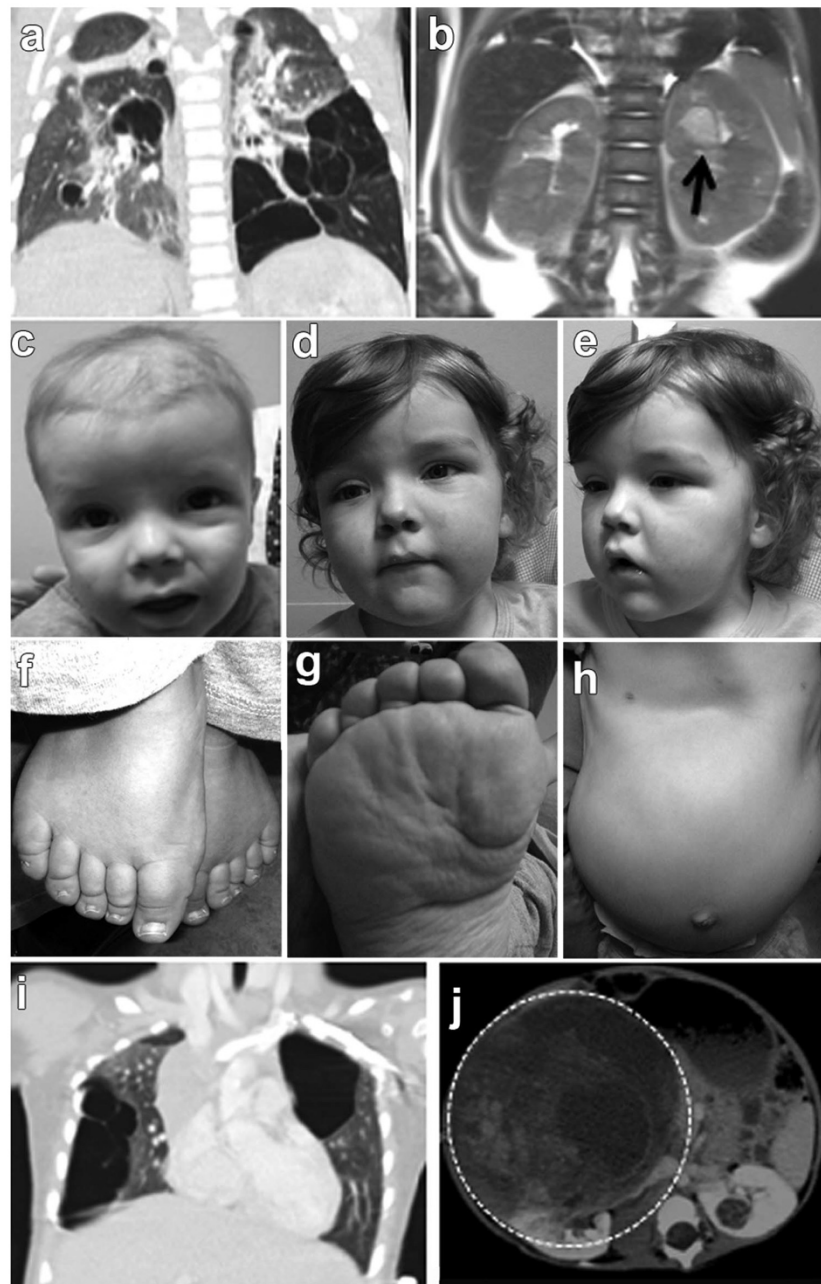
Phenotypic features of GLOW syndrome. (A) Coronal view of bilateral lung cysts of Case 1. (B) Case 1 at 9 months of age. MRI shows Wilms tumour in the left kidney (arrow). (C–E) Facial features of Case 1 at 9 months (C) and 28 months of age (D–E) including frontal bossing, a very large anterior fontanelle, hypertelorism, anteverted nares, a flat nasal bridge and slight micrognathia. (F–H) Additional findings in Case 1 at 28 months of age included (F) fat pads on dorsum of foot and toes, (G) rugated soles of feet with skin folds and (H) protuberant abdomen. (I) Coronal views of bilateral lung cysts of Case 2 at the age of 21 months. (J) Case 2 at 13 months of age with Wilms tumour (outline) in the right kidney, with associated ‘claw sign’.
